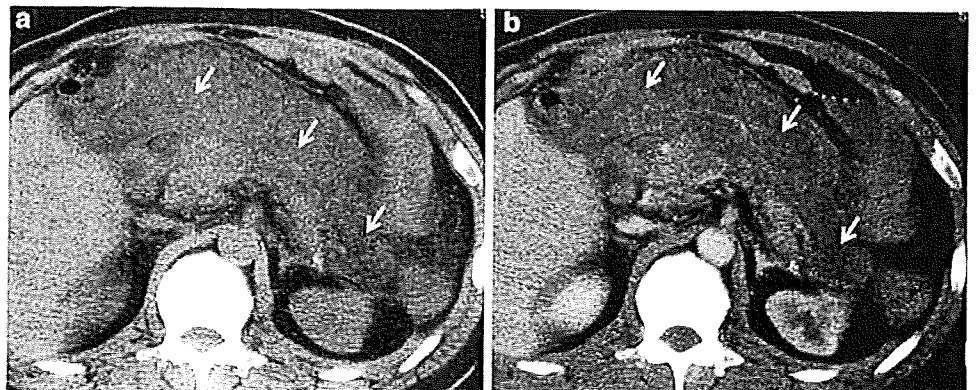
Plain CT (a) and contrast-enhanced CT (b) show fatty necrosis (arrows) in mesentery
